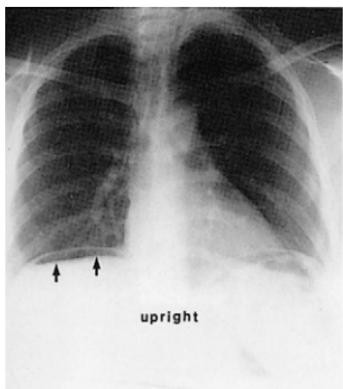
The upright chest x-ray shows free air under the right hemidiaphragm.
